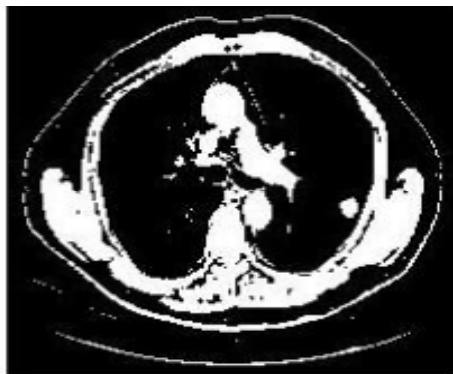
Binary Image From Segmented CT image
